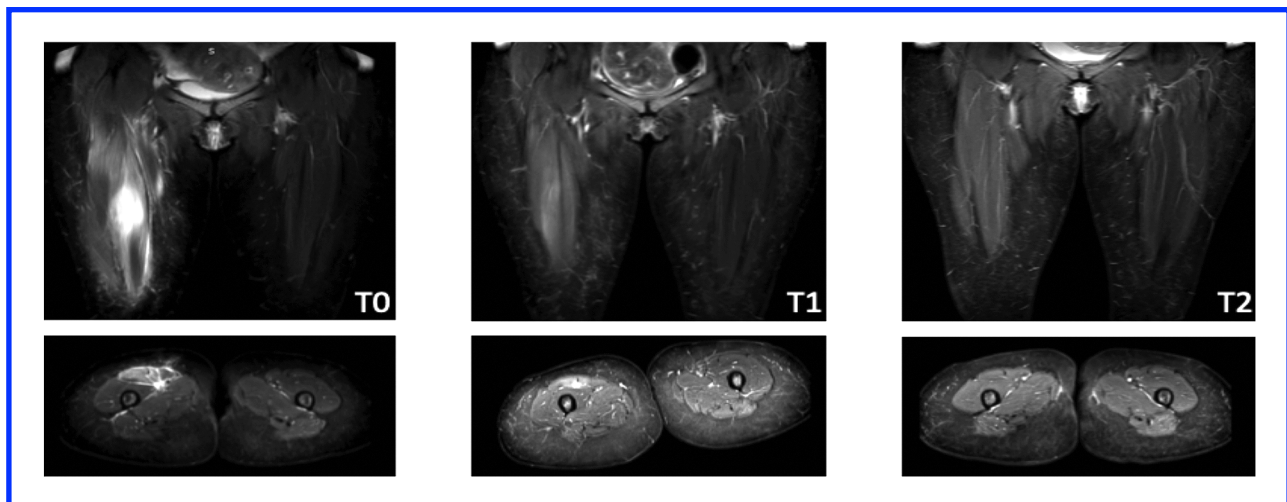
Muscle MRI (STIR_longTE sequences) at T0 (acute phase), T1 (at 4 weeks after T0) and T2 (at 8 weeks after T0).
